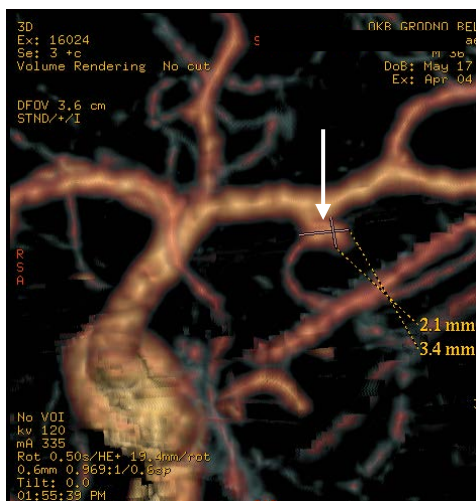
3 D spiral CT. Aneurysm at posterior brain artery (arrow)
